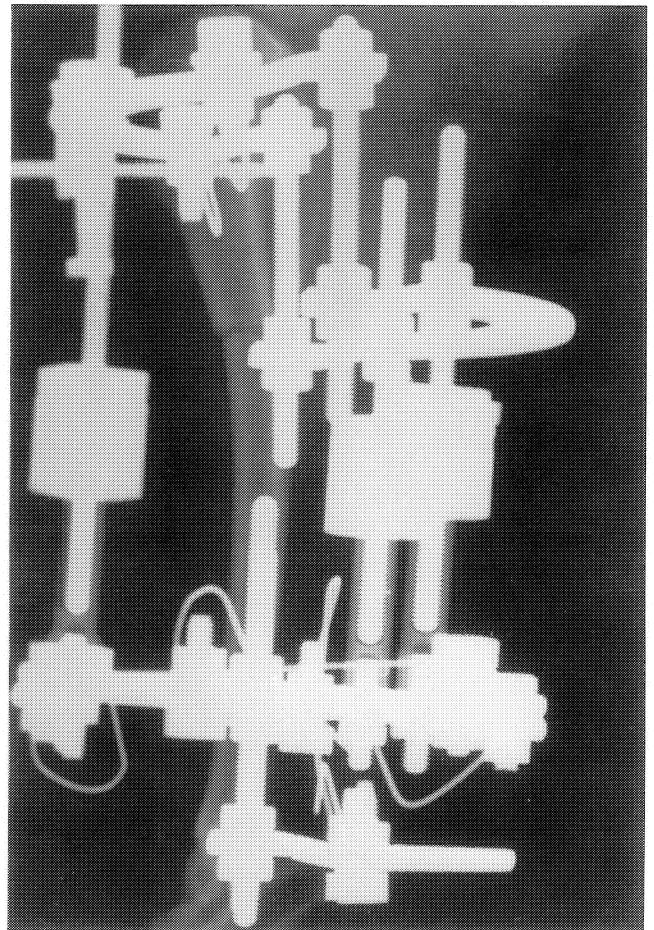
Post-operative lateral roentgenogram showing adequate reduction and good alignment of bone fragments.
